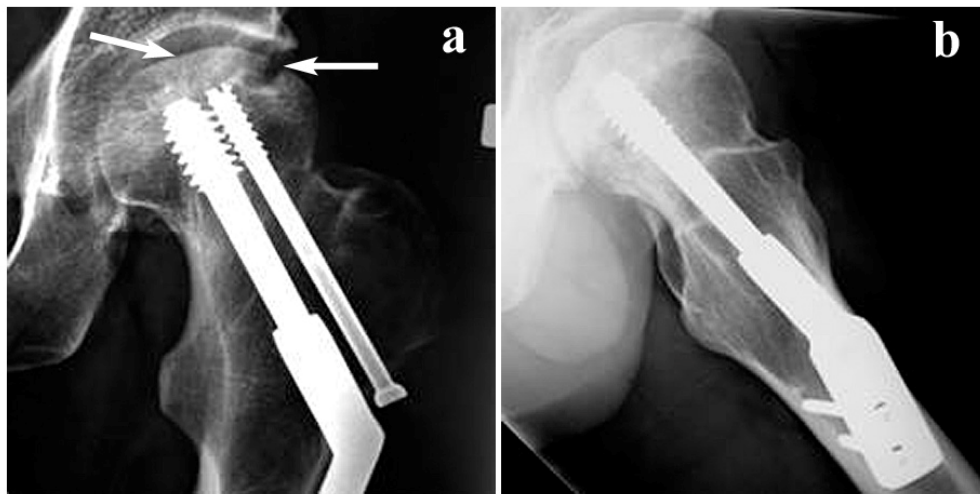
Pre-op radiographs (Case 2). Radiographs taken 18 months post fixation of intracapsular femoral neck fracture demonstrated evidence of advanced AVN.
